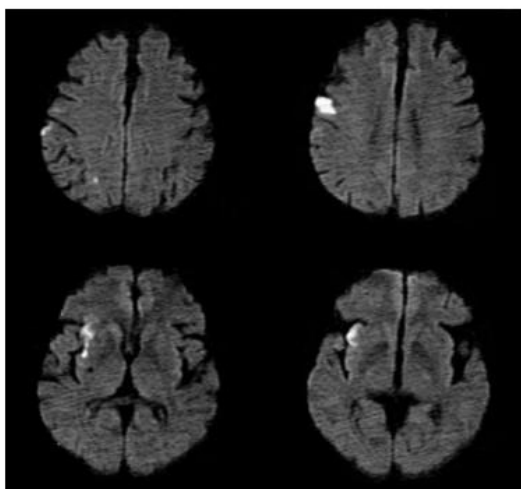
Identification of Embolic Stroke Patterns by Diffusion-Weighted MRI.¹¹
